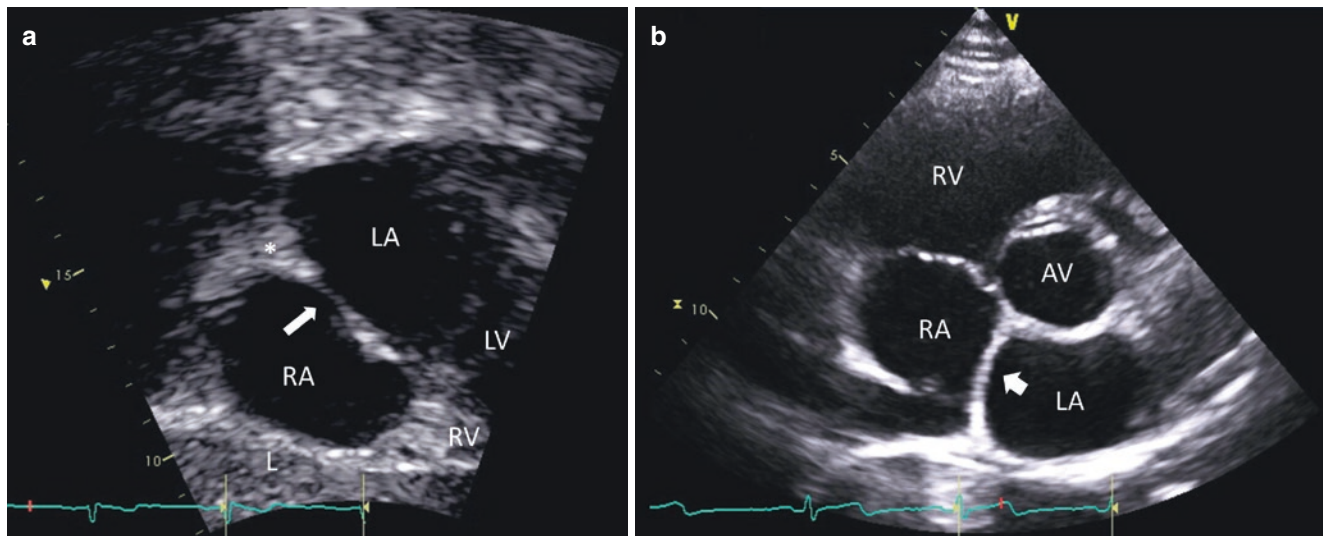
Normal atrial septum. (a) Subcostal four-chamber (congenital format) view showing the normal atrial septal anatomy. The transducer is placed in the subxiphoid region, lying almost horizontal with the probe marker in the 3-o'clock position. Alternatively, if the "adult format" is chosen (liver on the top of the screen), the probe marker should be held at the 9-o'clock position. The thin arrow points to the oval fossa, located between the superior (asterisk) and inferior limbi. This is the most commonly used view for the evaluation of the atrial septum. (b) The parasternal short-axis
